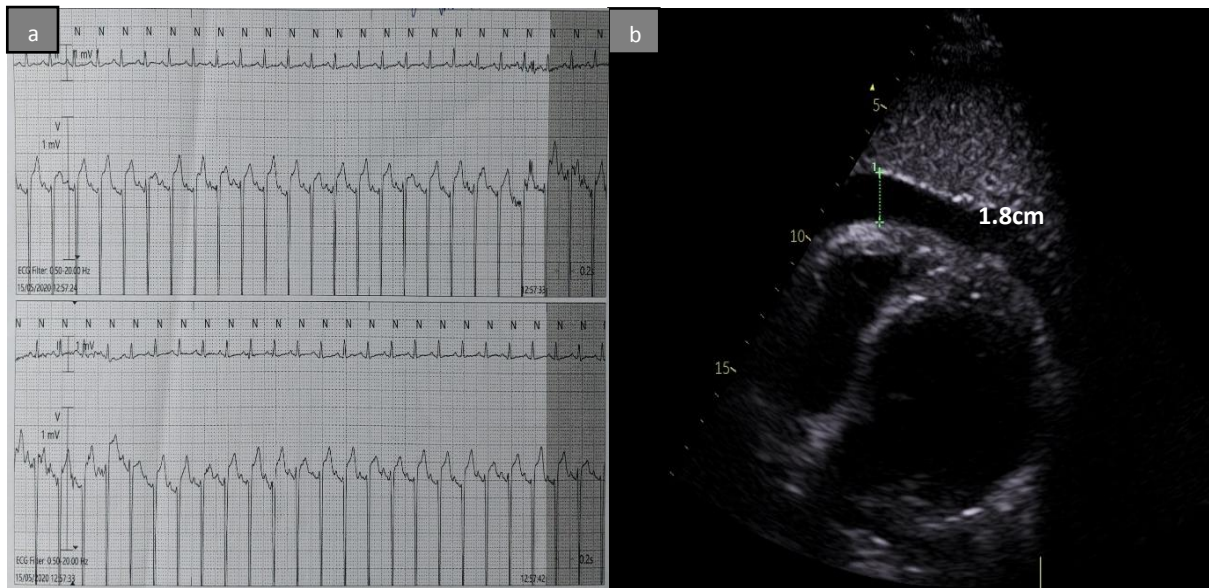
(a) Telemetry image shows sinus tachycardia at 150 beats per minute. (b) Transthoracic echocardiography shows that the pericardial effusion has enlarged with a maximum intra-pericardial separation of 1.8 cm (line).
